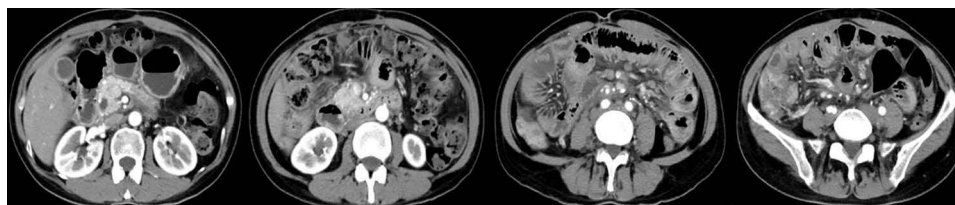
CT scan shows the tumor in gall bladder and metastatic lymph nodes on December 31, 2021.
